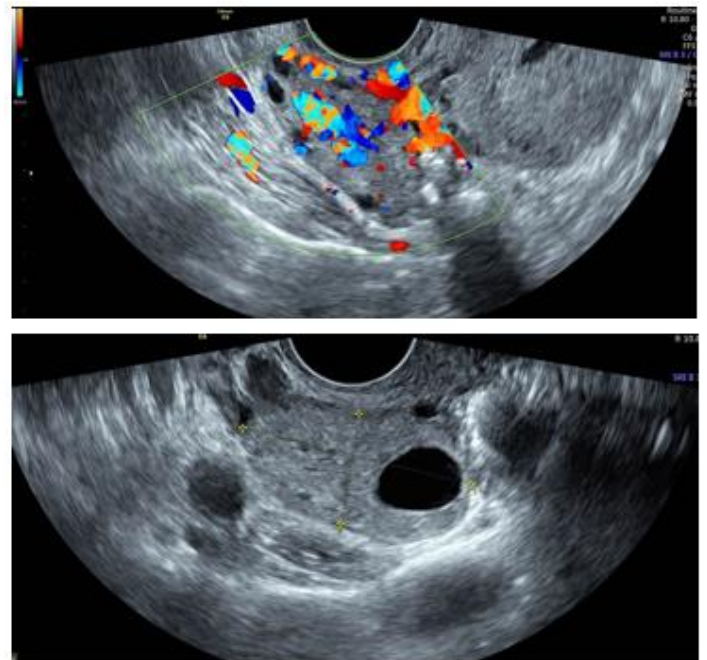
Preoperative images of ovarian torsion ovarian showing edema ovary with less vascularity-ultrasound and mri image.
